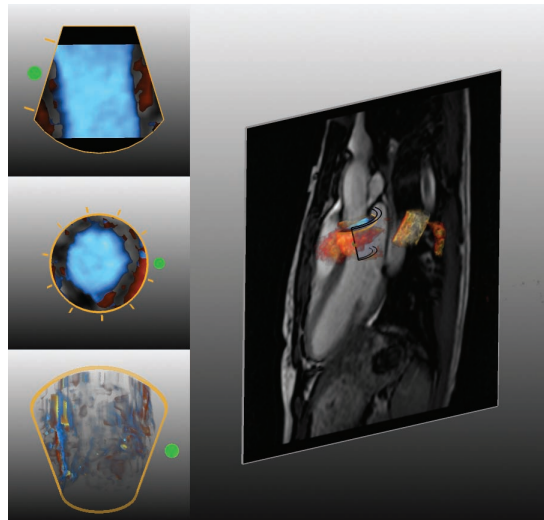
Compound view of blood flow near the aortic valve of a healthy volunteer. To closely inspect the hemodynamics around the valves, the field-of-view is narrowed to gain temporal resolution. Instead of a volume rendered anatomical context, an cine anatomy slice is acquired. The velocity-field volume rendering shows incoherence in noisy regions surrounding the vessel. Some regions are strongly regurgitant. They are conveyed in yellow, based on the Doppler US inspired transfer function (Fig. 8.6d).
